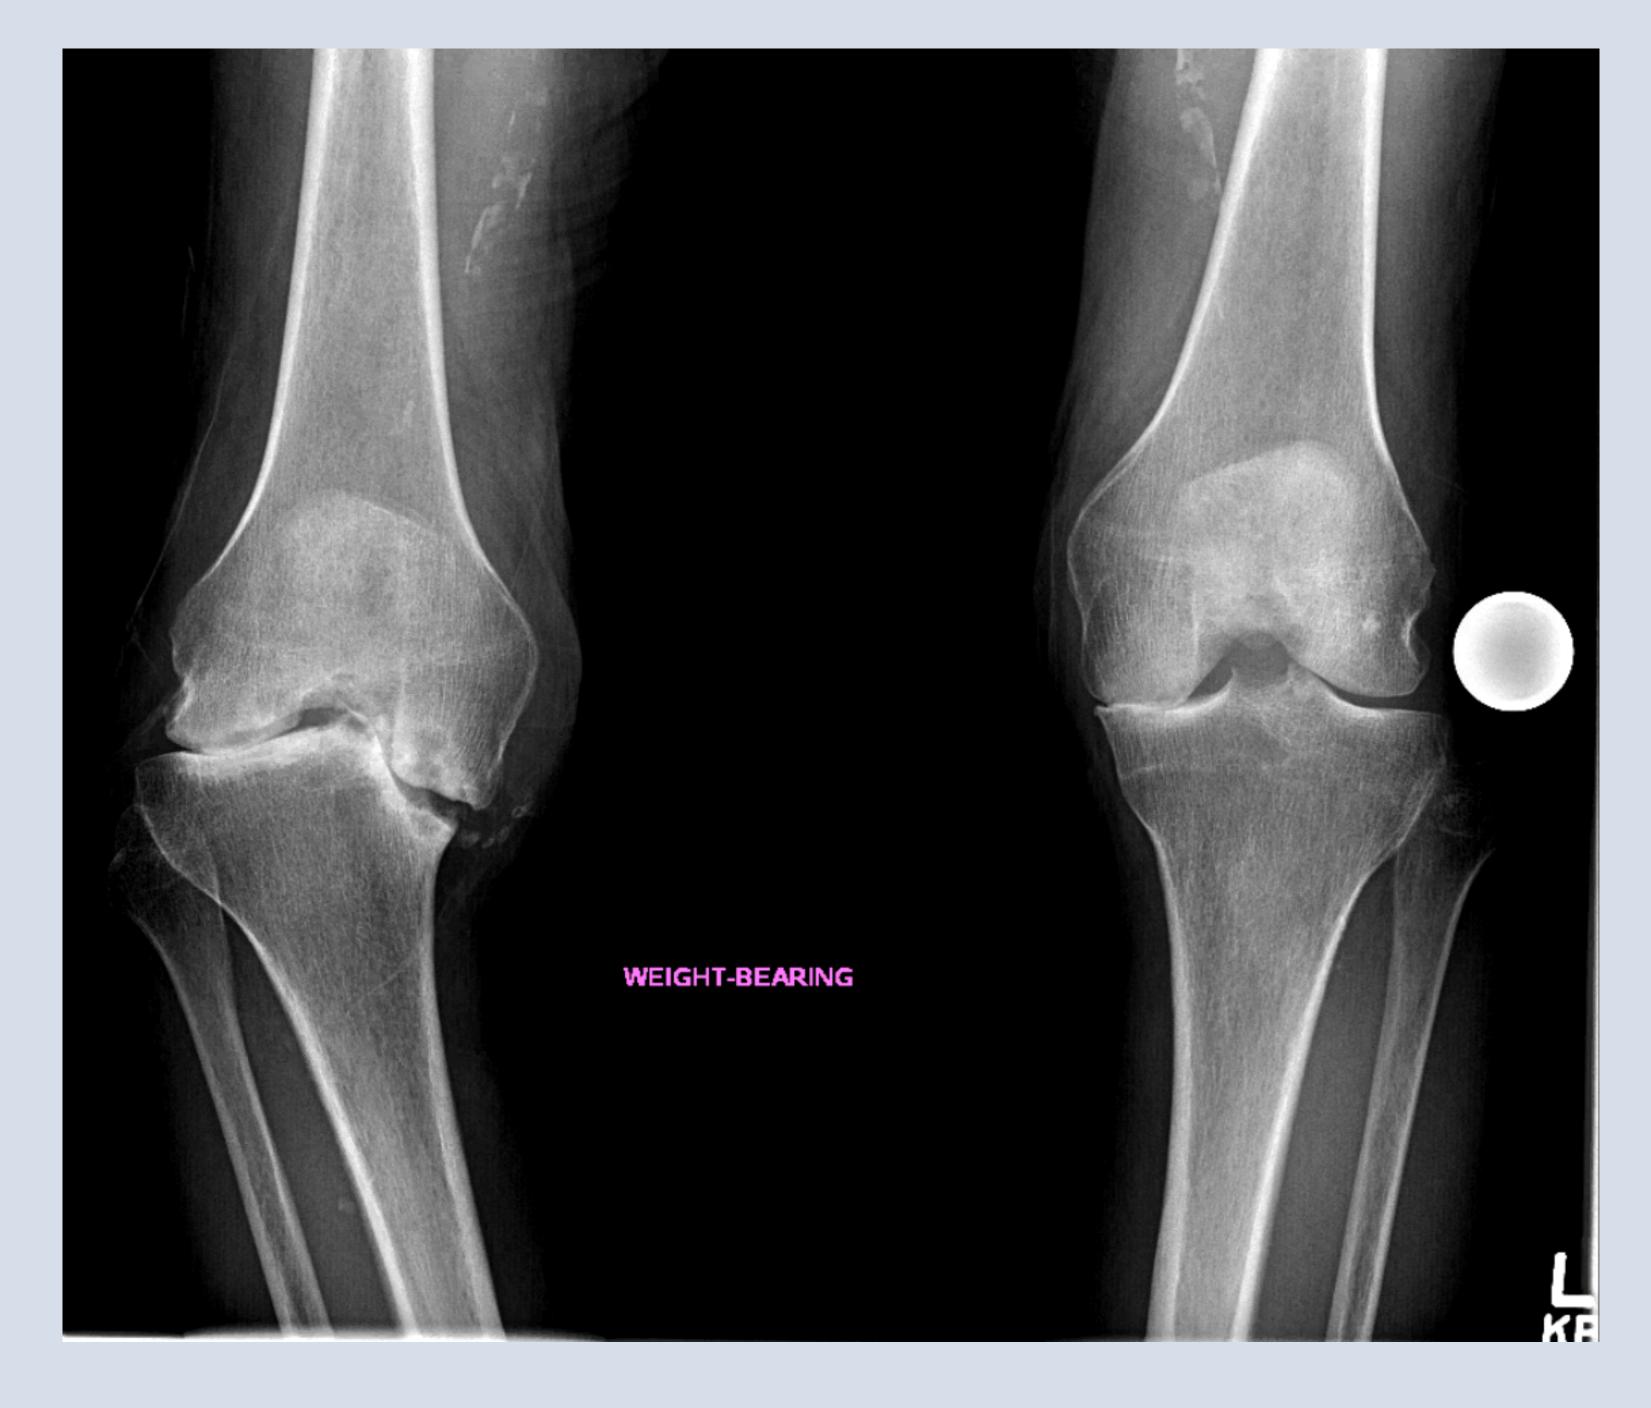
Weight-bearing anterior-posterior (AP) X-ray of revealed right medial tibial plateau fracture and large medial femoral condylar osteochondral injury.
